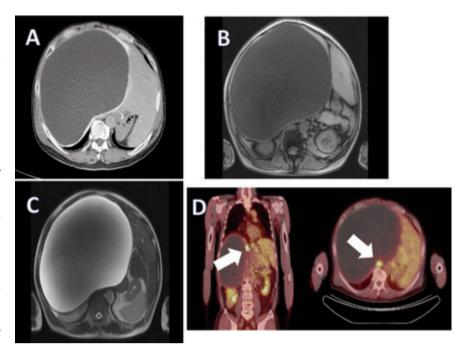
Computed tomography scan (A) and magnetic resonance imaging (B, C) demonstrating an extremely large, cystic mass in the right hepatic lobe. T1-weighted images (B) and T2-weighted images (C). ¹⁸F-fluorodeoxyglucose positron emission tomography scan with an area of FDG avidity (arrow) in the cyst wall (D).
